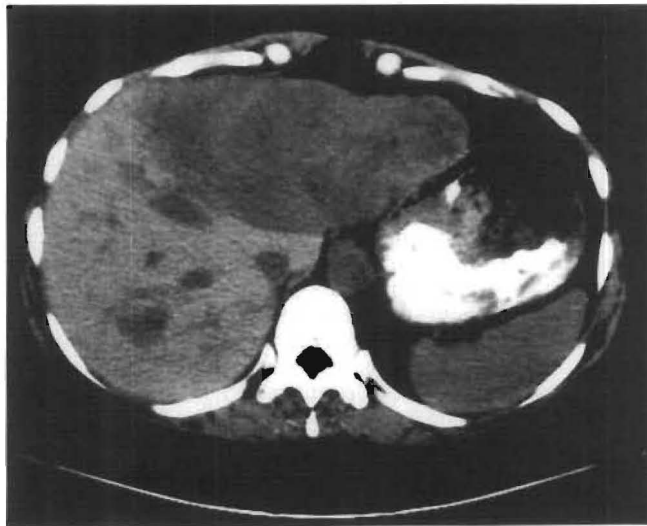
Pre OLTx CT scan, case no. 5. A large hypodense lesion is demonstrated involving the entire left hepatic lobe with extension into the anterior segment of the right lobe. There is an additional smaller round lesion in the posterior segment of the right lobe
